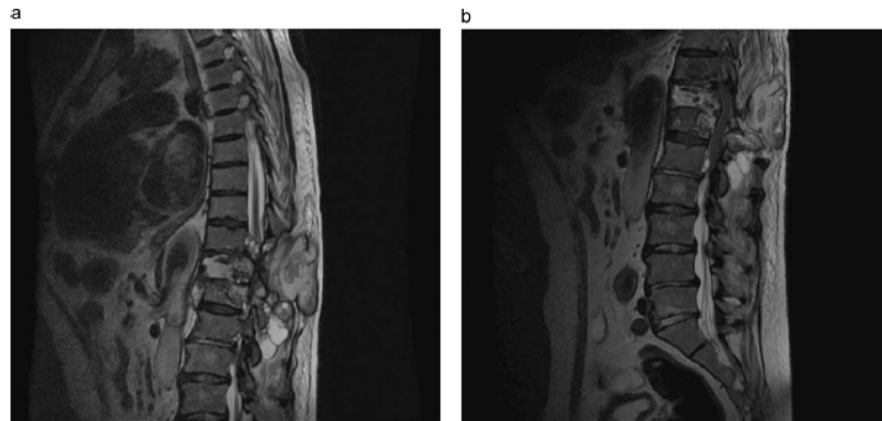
Sagittal section MRI shows a paravertebral mass with destruction of T11, intraspinal invasion, and medullary compression.
